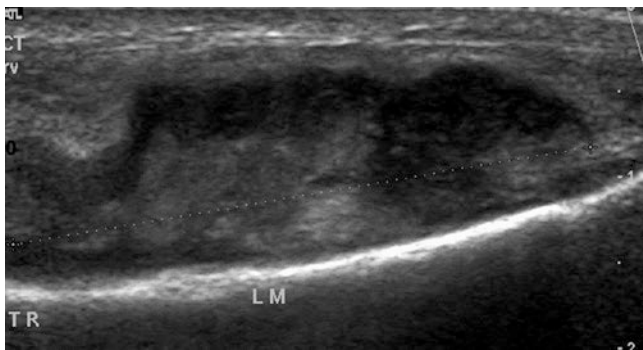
Ultrasound of the distal femur allows real-time visualisation of abscess formation
